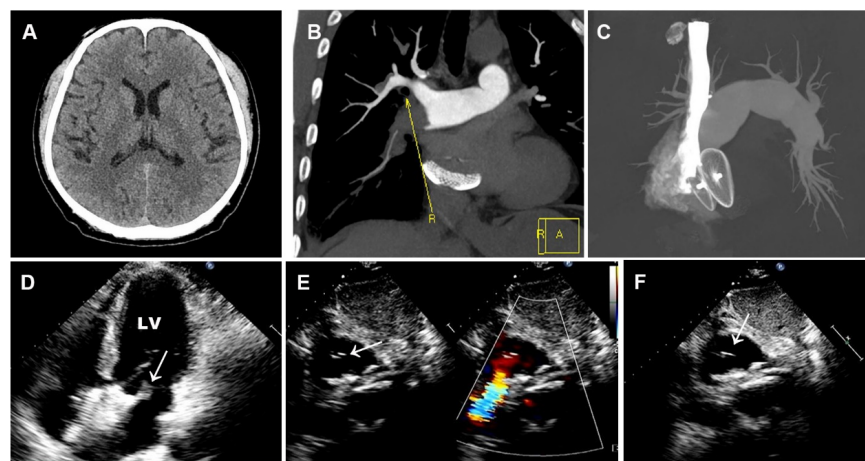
Preoperative imaging examination. (A) Brain CT manifested as post-infarction of cerebral lacunar with no other significant abnormalities. (B-C) Pulmonary CT angiography presented embolism in the distal of the right pulmonary artery and its branches. (D-F) Preoperative TTE showed a 13×9 mm thrombus floating in the left atrium without shunt. White arrows represent thrombus.
